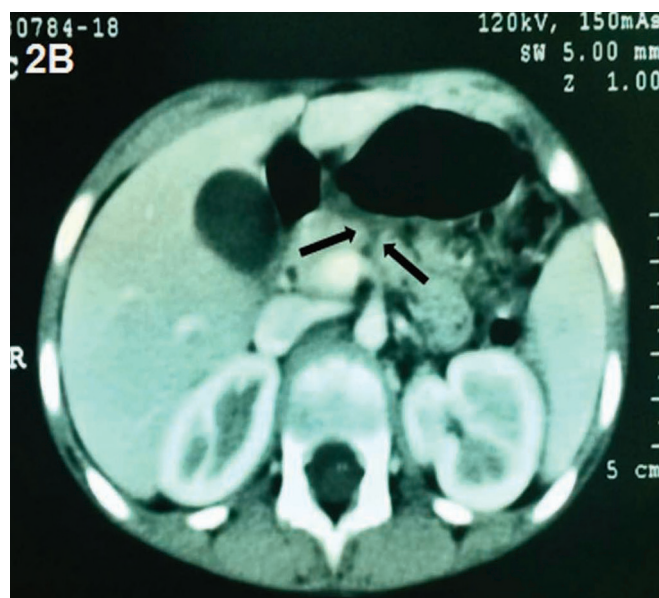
Repeat CT scan after 8 weeks showing a linear hypodensity (arrow) (much smaller than before) in the neck of the pancreas suggestive of resolving hematoma.
